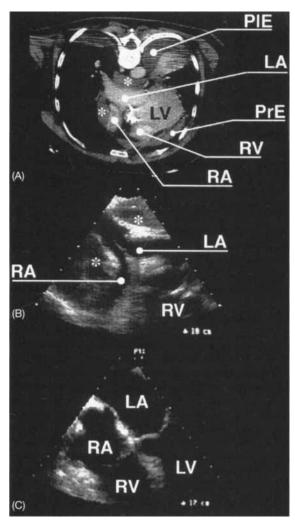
(A) Computed tomographic angiography of the chest. A small pericardial effusion surrounding the right ventricle anteriorly is seen with selective bilateral atrial compression by two masses. (B) Transesophageal echocardiogram, four-chamber view, showing two large pericardial clots (*) compressing both atrial cavities. (C) Reexpansion of the right and left atria is noted after evacuation of the clots. LA = left atrium, RA = right atrium, LV = left ventricle, RV = right ventricle, PIE = pleural effusion, PrE = pericardial effusion.
